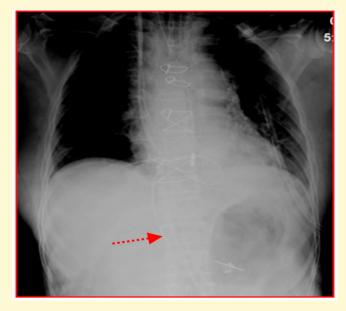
Frontal Chest Radiograph Showing SGC in Inferior Vena Cava (IVC)
